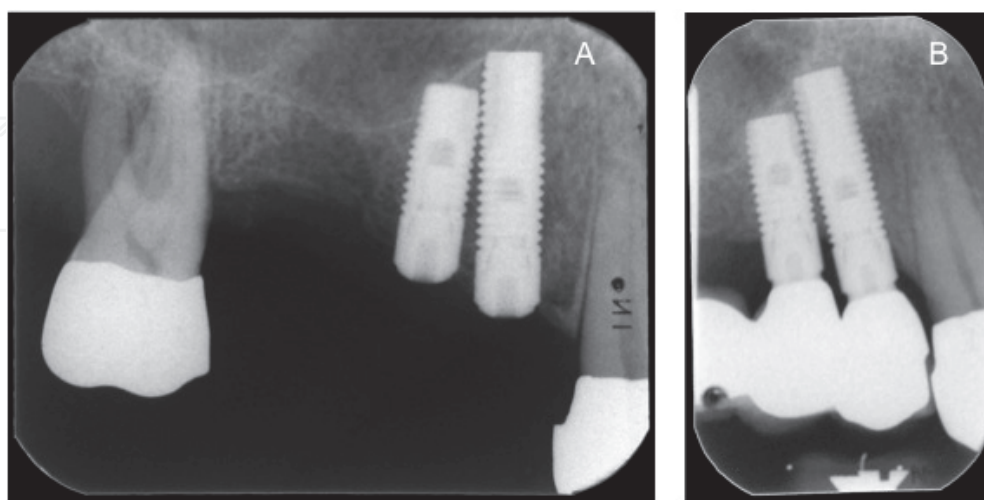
Radiographs of implants at #4 and #5 position placed with an inter-implant distance less than 3mm. Note the marginal bone loss between implant installation (A) and prosthesis delivery (B).
